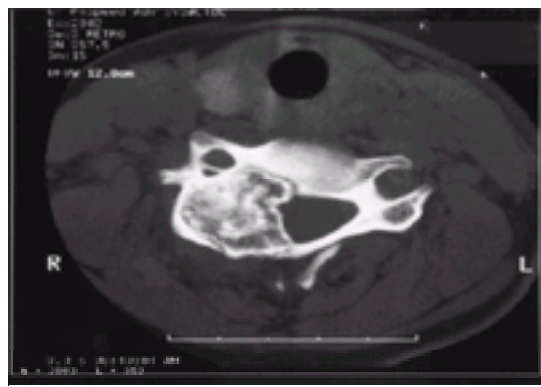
Osteoblastoma of the cervical spine: on this axial CT scan the lesion is seen to arise from the right pedicle and compromise the canal; it should be removed surgically.
